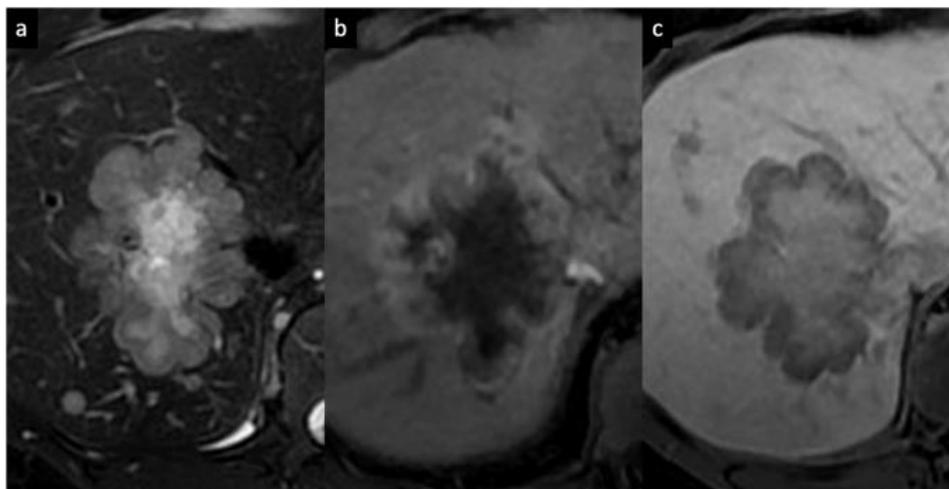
Synchronous liver metastasis from invasive ductal carcinoma of the breast in a 47-year-old woman. a Axial fat-suppressed T2-weighted MRI shows a large focal liver lesion with a central fibrotic component, depicted as an area of hyperintensity, whereas peripheral viable tumor is depicted as an area of moderate hyperintensity; this contrast between the peripheral and central areas is described as the so-called “target sign”. b Gadoxetate disodium-enhanced MRI demonstrates a rim APHE surrounding a central hypointense area. c The hepatobiliary phase shows a “cloud-like” appearance with a central portion that is relatively hyperintense compared to the hypointense peripheral area (“targetoid appearance”). A biopsy of the lesions confirmed the diagnosis of liver metastases from breast cancer [52].
